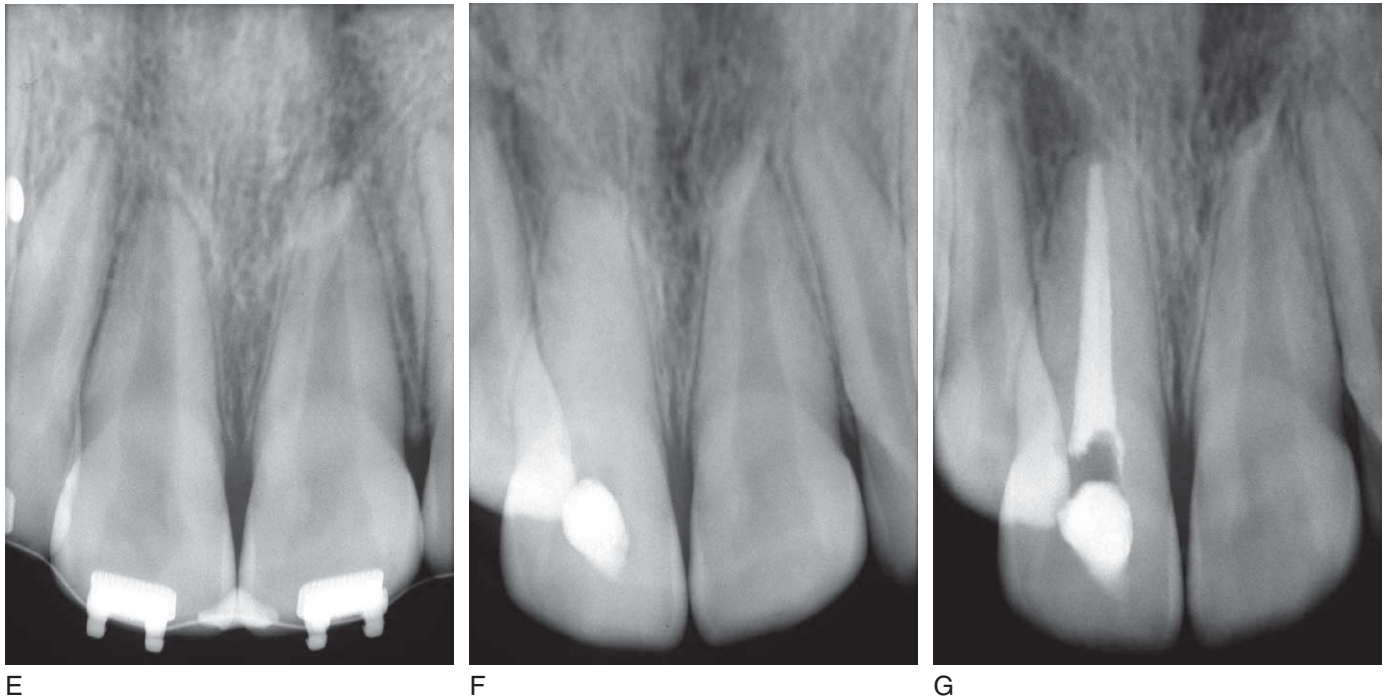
cont'd E, Radiograph showing tooth in proper position. F, Radiograph showing endodontic treatment with calcium hydroxide applied within the canal. G, Radiograph showing final canal obturation 2 years after initial trauma. Note apical root resorption.
